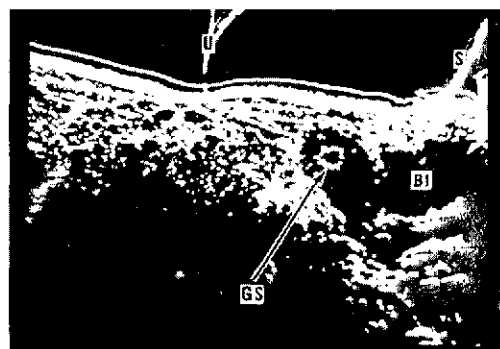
Sonograms showing growth of pregnancy from fifth week to term. Top, from left: 5 weeks and 11 weeks. Bottom, from left: 13 weeks and 37 weeks. U, umbilicus; S, symphysis; GS, gestational sac; Bl, bladder; Ut, uterus; F, fetus.
